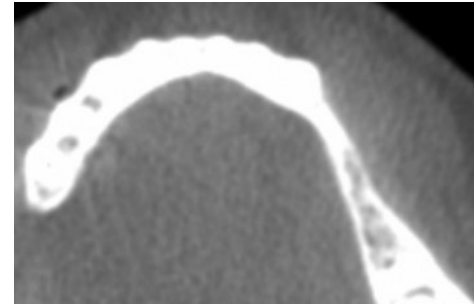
Pre-operative CBCT scan, axial view.
